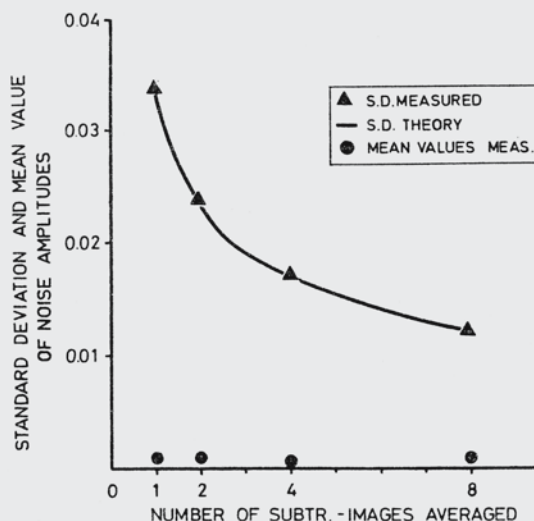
Decrease in RMS-noise amplitudes by averaging together increasing numbers of subtraction images according to the scheme of Fig.5. The pictures processed were recorded at constant x-ray intensity. The standard and the mean deviation from the expected zero density change was calculated for 4 K pixels in the center of each of the four averaged subtraction-images. Mean brightness in this image region was about 40 % of maximum brightness. The theoretical curve decreases inversely with the square root of images averaged.
